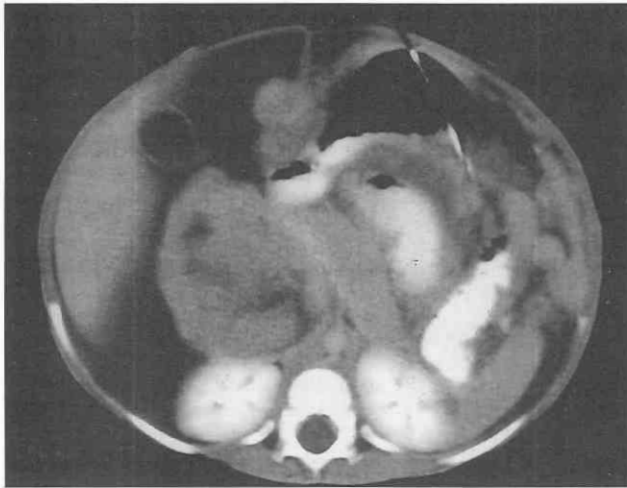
Rounded omental metastasis. CT scan through the upper abdomen demonstrates a rounded, heterogeneous mass in the lesser omentum, representing metastatic disease.
